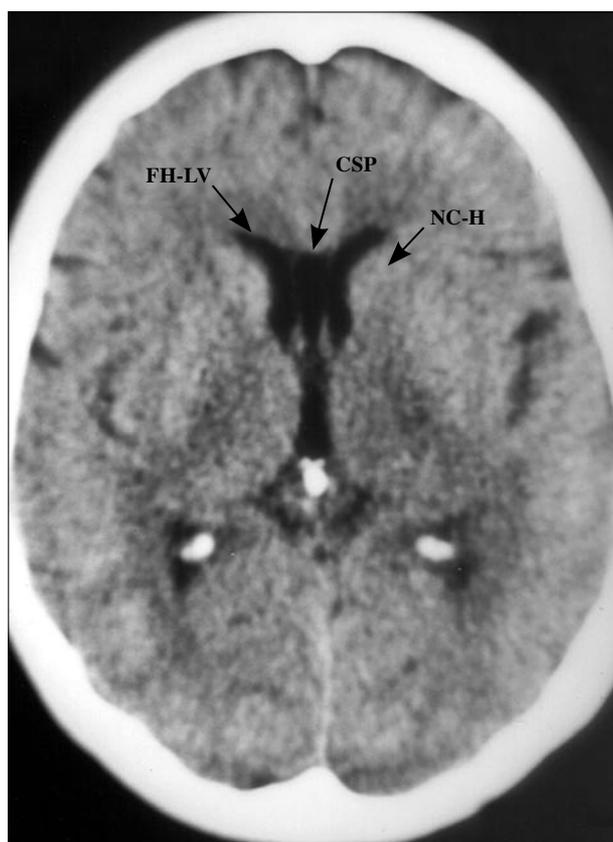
CT scan of cavum septi pellucidi (CSP) in our patient. Frontal horns of the lateral ventricle (FH-LV). Head of the caudate nucleus (NC-H).
